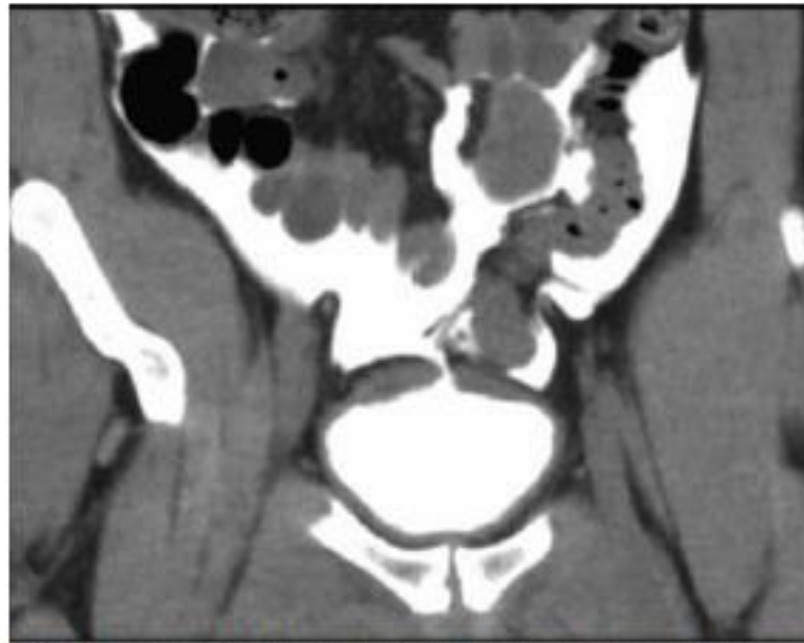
Computed tomography, contrast demonstrates contrast
